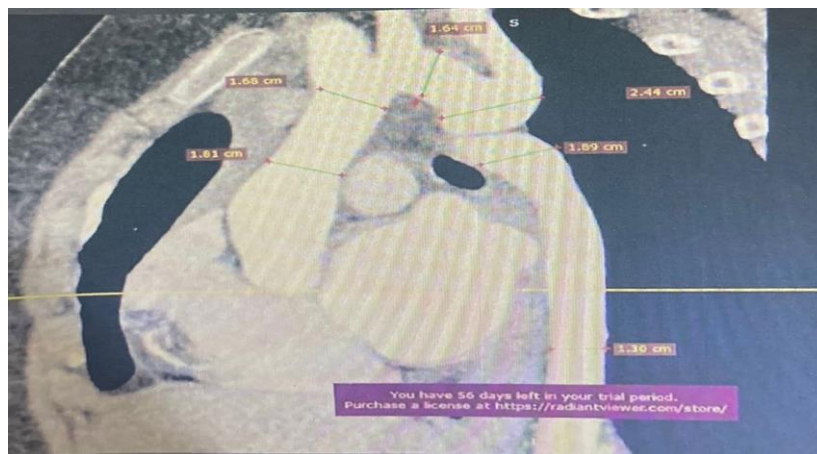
CT angio of patient with proximal , distal arch and, descending).
